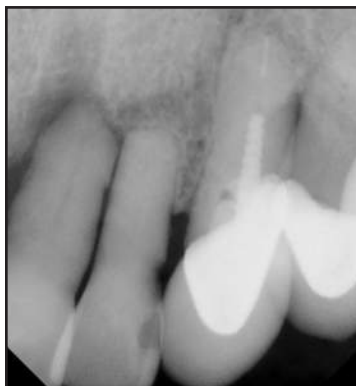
Pre-treatment radiograph of hopeless teeth #9-10.
